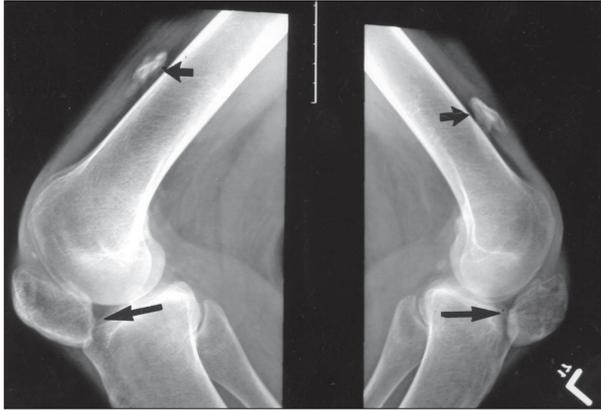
Lateral computed radiographs demonstrating a patella Baja (low lying patella), (long arrows) and calcification of the tip of a ruptured retracted quadriceps tendon bilaterally (short arrows).
